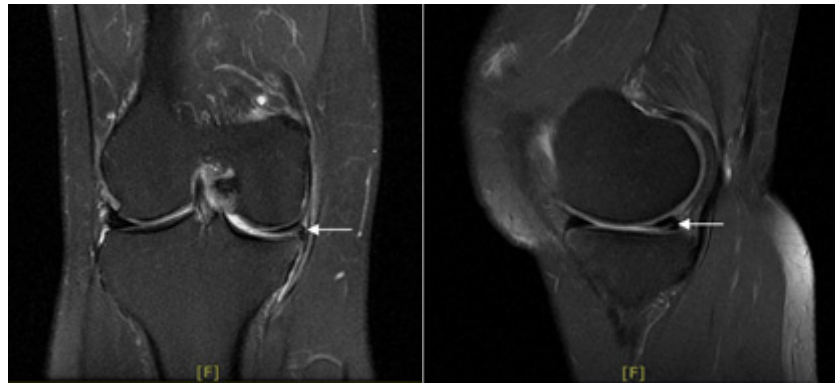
Right knee MRI of case 5 (12/12/2019).
